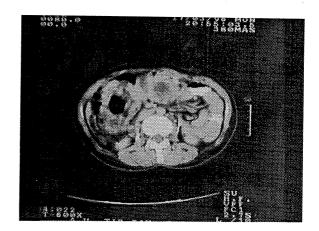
B Targetlike Appearence in Computed Tomogram of the Same Patient.
